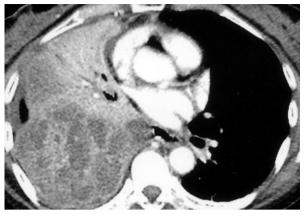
Chest CT showed a huge mass lesion with an internal septation/solid component and central necrosis noted at the right lower lobe, measuring about 13 cm at its longest diameter. Rapid progression, as compared with the CT 1 month previous to this, was revealed.
